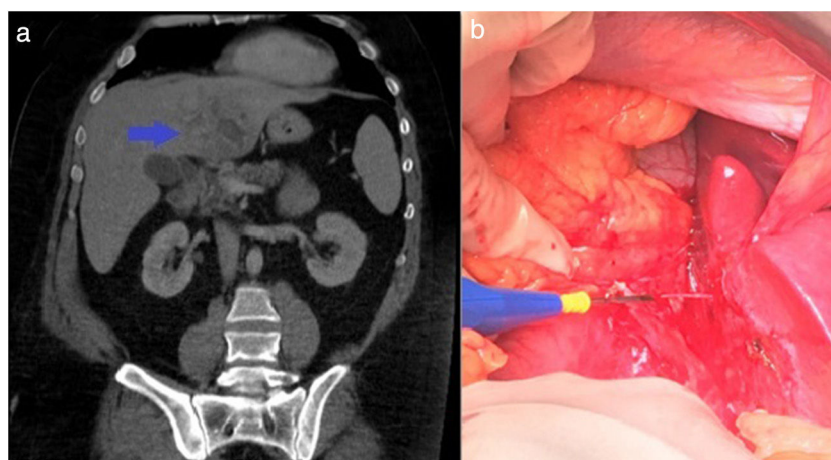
(a) Axial slice of the CT scan, showing intrahepatic abscess in the left hepatic lobe indicated by the blue arrow; (b) intraoperative image during the extraction of the fishbone from the liver. The figure colors can only be seen in the electronic version of the article.
